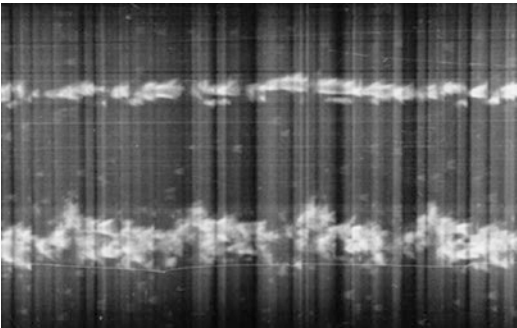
The first echocardiographic recording is displayed as a “motion-mode,” or M-mode, tracing displaying ultrasonic tracings of the left ventricular posterior wall [23]
